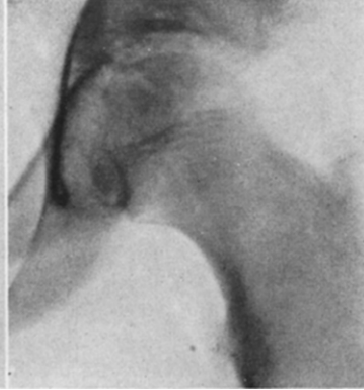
Case xxii. Roentgenogram two years later, June 2, 1939; focus in acetabulum healed; focus in head still present; beginning spur formation.
